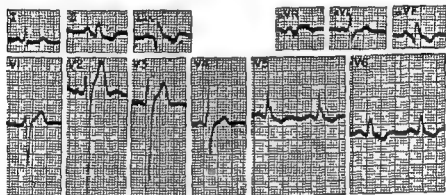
Left bundle branch block with old posterior myocardial infarction. The QRS complex measures 0.12 second. A late intrinsic deflection and a turret-topped QRS complex in Lead  $V_6$  suggests left bundle branch block. The broad Q wave in Lead  $aVF$  establishes the existence of an old posterior myocardial infarction. The Q wave in Lead  $V_6$  may be explained by septal infarction permitting passive transmission of right ventricular potentials to the left side of the precordium. The patient was a 65-year-old man who had an acute posterior occlusion five months previously. Roentgen ray examination showed calcification in the descending branch of the left coronary artery.
